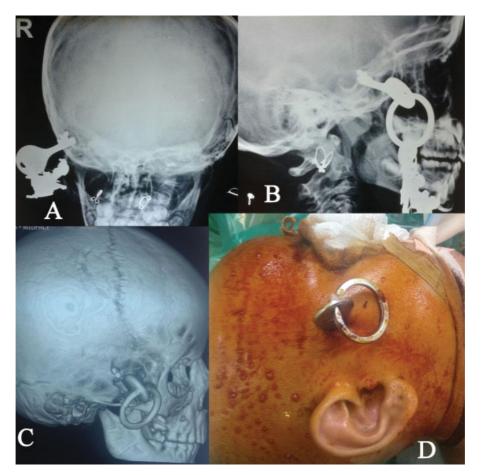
(A) AP X-ray of the skull, (B) lateral X-ray of the skull, (C) three-dimensional bone window computed tomography scan, (D) clinical photograph of patient. AP, anteroposterior.
